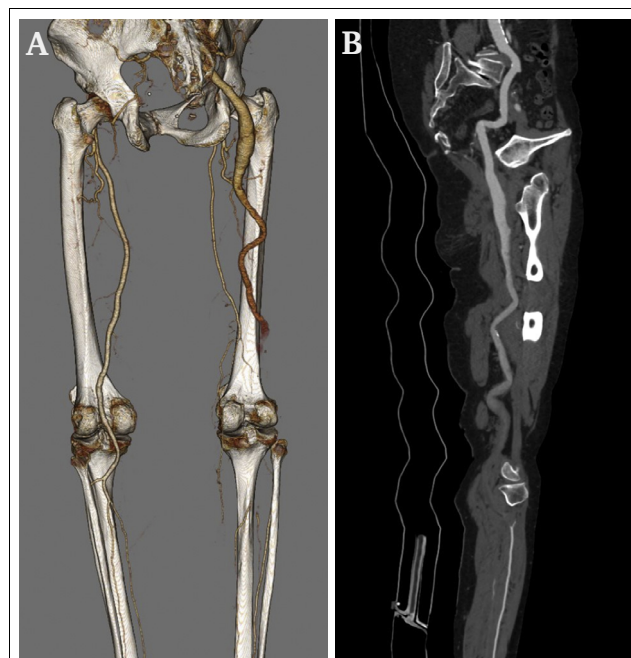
Aneurysmal persistent sciatic artery with acute thrombosis of the popliteal artery. Computed tomography angiography: (A) three-dimensional reconstruction and (B) centre line reconstruction.
